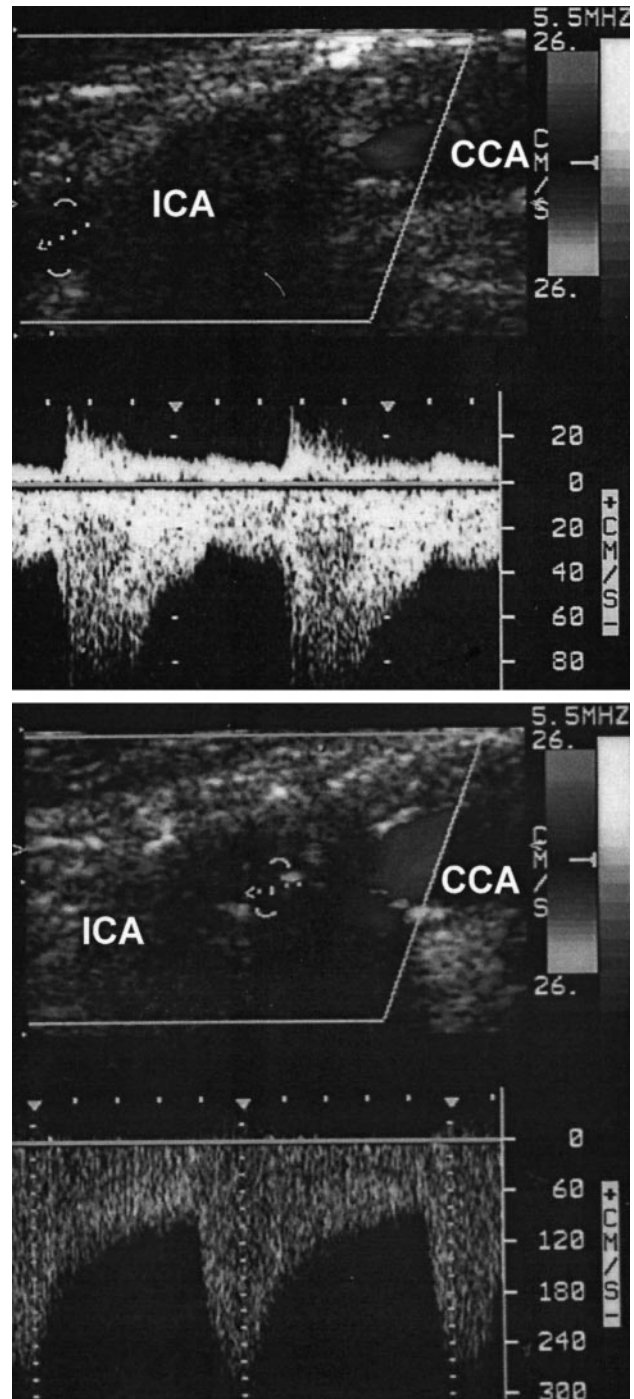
Left ICA of patient 10 with high-grade stenosis. Below the B-mode scans are the corresponding pulsed-wave Doppler spectra. In the precontrast investigation (upper templates), only a poststenotic signal, not an intrastenotic Doppler spectrum or a color-coded Doppler flow signal, can be recorded. The echocontrast investigation allowed the identification of part of the residual lumen in the stenosed ICA. The pathologically high flow velocity in the enhanced investigation within the stenosis (lower templates) helps to quantify the stenosis. Note the different scales on the y axes of the Doppler spectra. CCA indicates common carotid artery.
